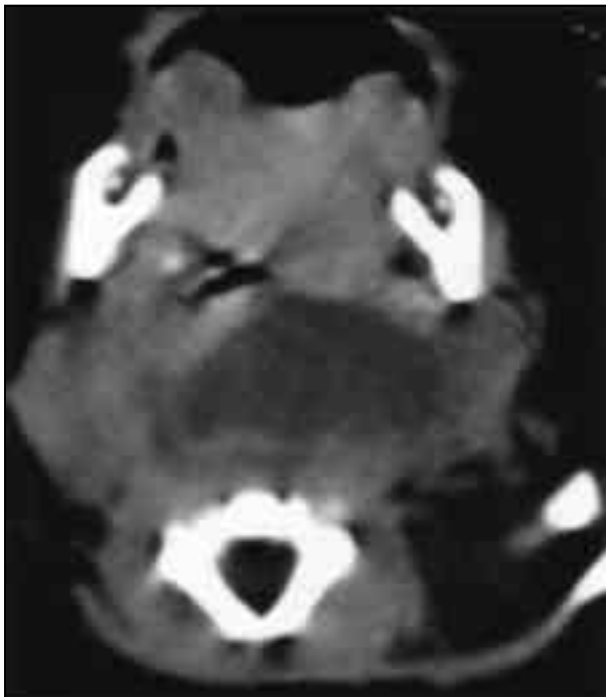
Plain CT scan neck showing fluid attenuating lesion in retro and left parapharyngeal space causing elevation and compression of airway
